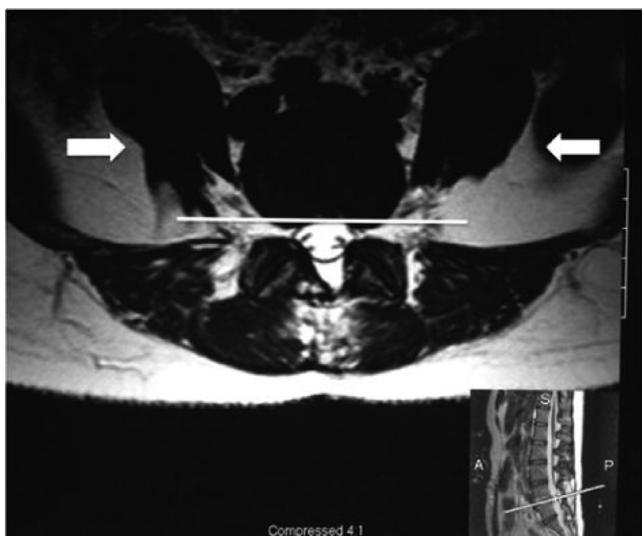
Axial T2-weighted MR image obtained in a 39-year-old female patient who underwent a lateral interbody fusion at L4-5 for degenerative disk disease. The psoas muscles are located ventral and lateral to the L4-5 disk space. She had persistent paresthesias and leg weakness for 6 months after surgery. Reprinted with permission from Voyadzis J-M et al.²⁹
